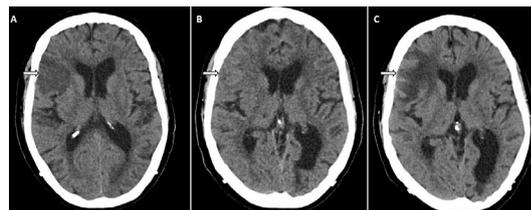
Non-contrast brain CT. (A) Initial CT shows right frontal hypodensity. (B) Subsequent CT shows the previously hypodense right frontal area is now isodense. (C) Repeat CT the next day showed expected evolutionary changes of the initial subacute infarct.
